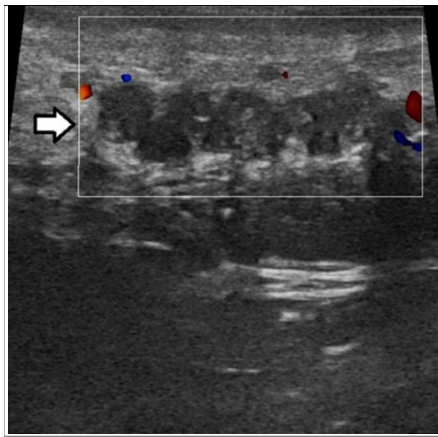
Colour Doppler ultrasound showing no flow in the spermatic vein.
